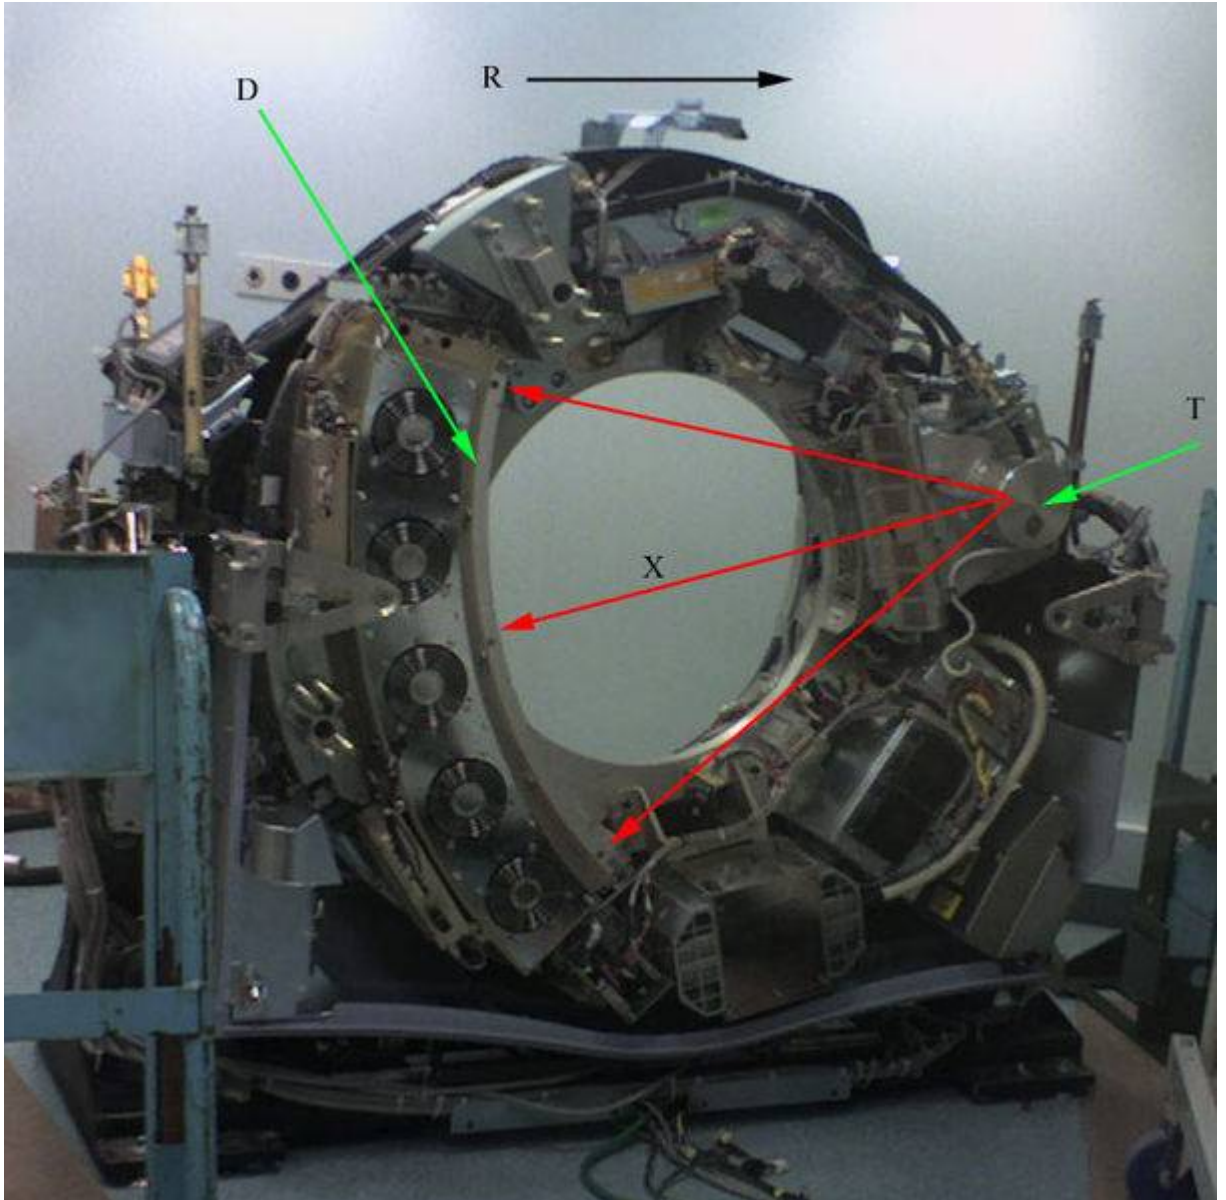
CT scanner with cover removed to show the principle of operation: *T* - x-ray tube, *D* - x-ray detectors, *X* - x-ray beam, *R* - Gantry rotation direction [12].
